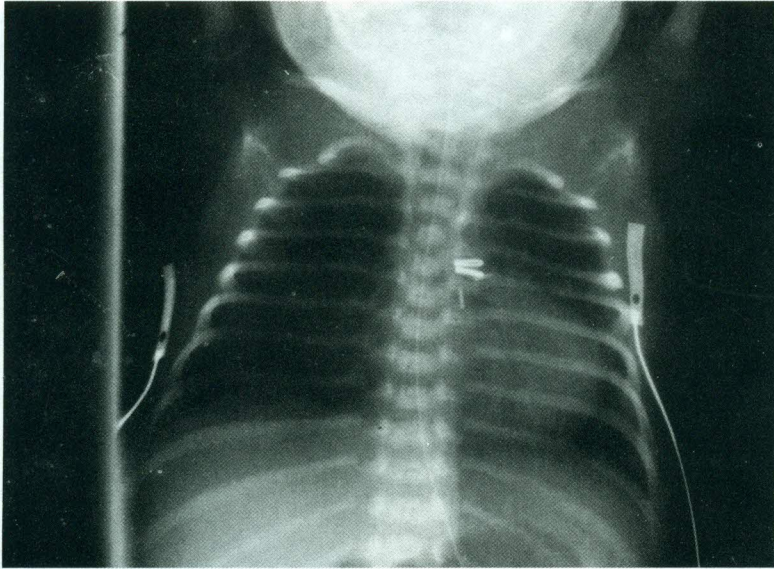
Postoperative chest X-ray showing clip at the site of the ductus, intercostal tube in place and patient is still on ventilator. However, pulmonary vascularity shows marked improvement if compared to the preoperative (Figure 2)
